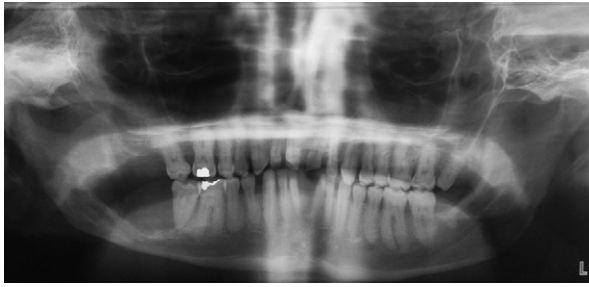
Panoramic radiograph undertaken for the reported case before the first general anesthesia indicated for dental extraction and tumor resection. A wide lytic lesion is observed behind the lower right second molar. Periradicular bone deposition is seen in the adjacent teeth.
